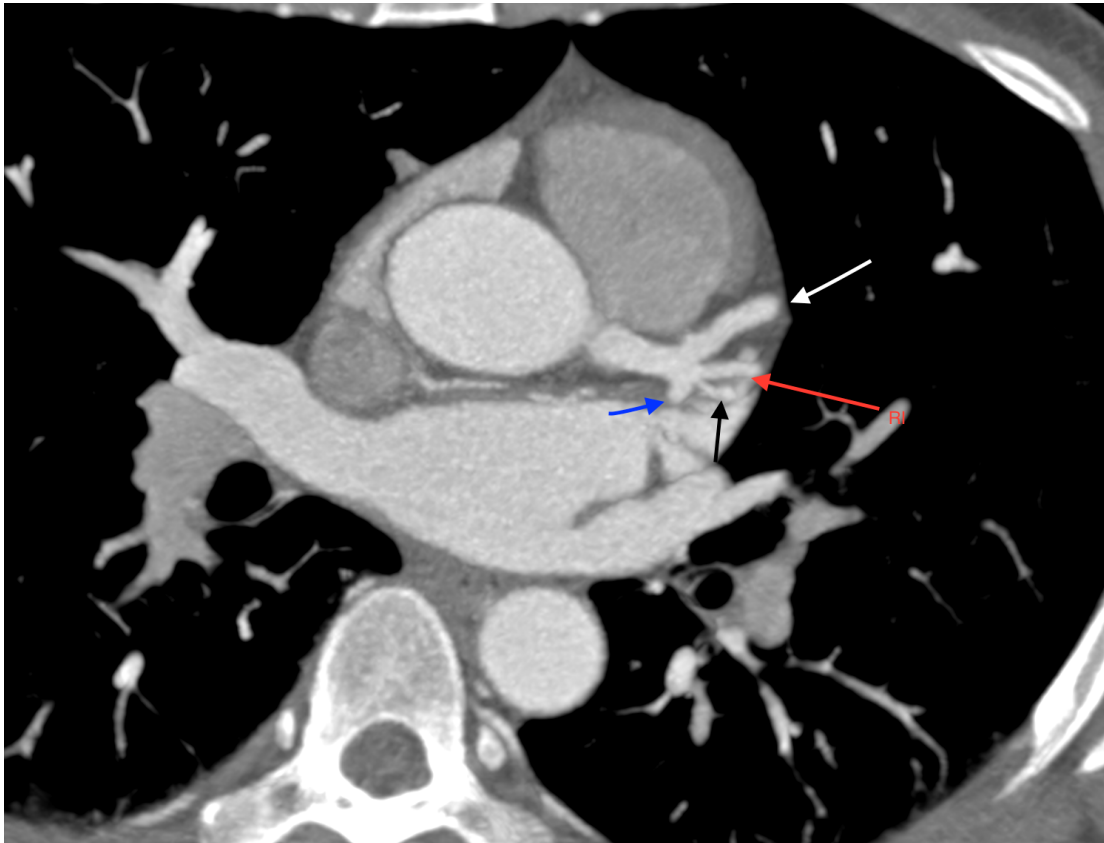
Axial CTA cardiac in a 65 years old man, showing trifurcation of LM coronary artery Ramus Intermedius (red arrow), Proximal Left circumflex artery (blue arrow) and Proximal Left anterior descending artery (white arrow).
